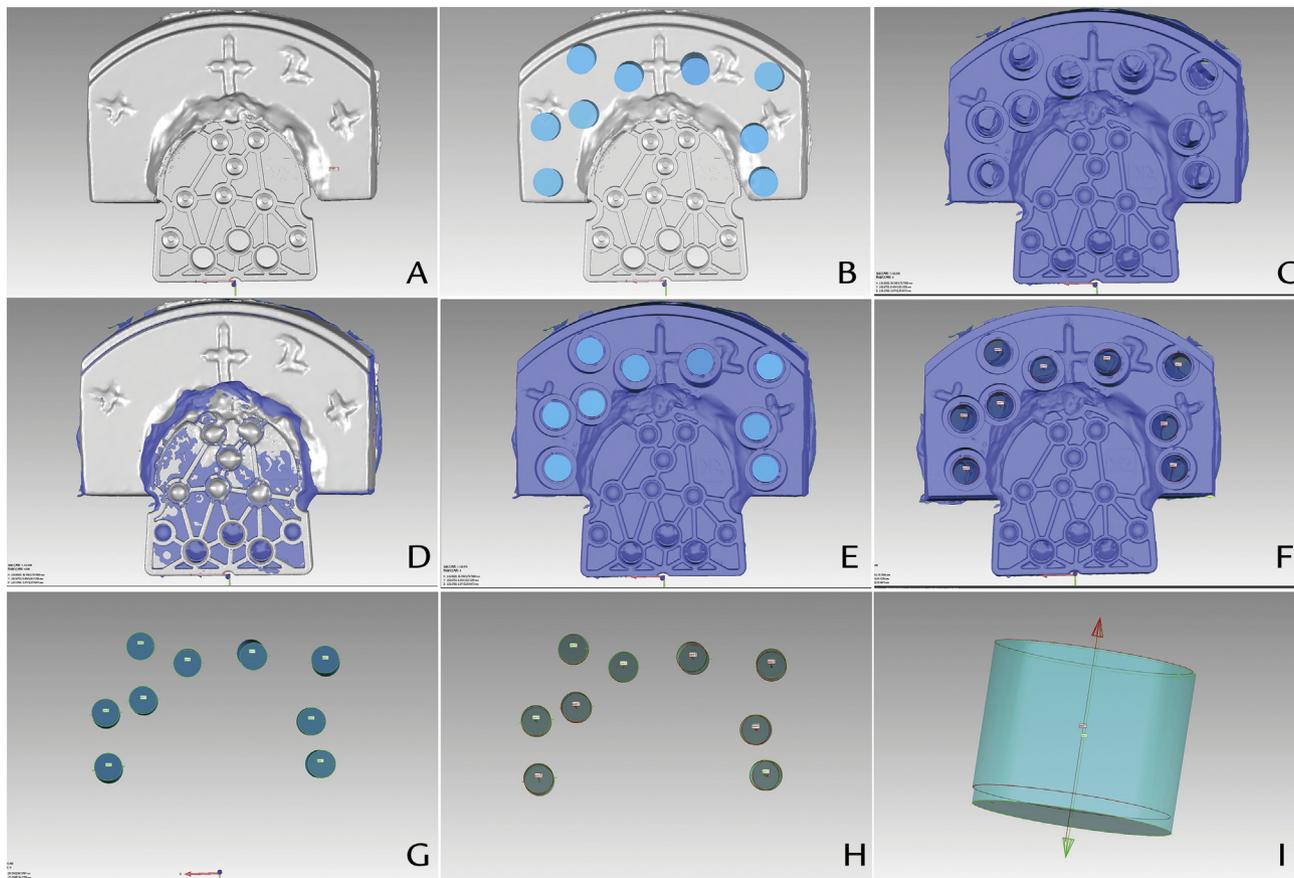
Accuracy evaluation process: A, Digitized radiographic guide imported into imaging analysis software program. B, Virtual implant planning and digitized radiographic guide in same coordinate system. C, Digitized surgical guide with actual milled sleeve bore holes imported into coordinate system. D, E, Digitized guides before and after milling superimposed by using characteristic grooves on surface of resin plate.
